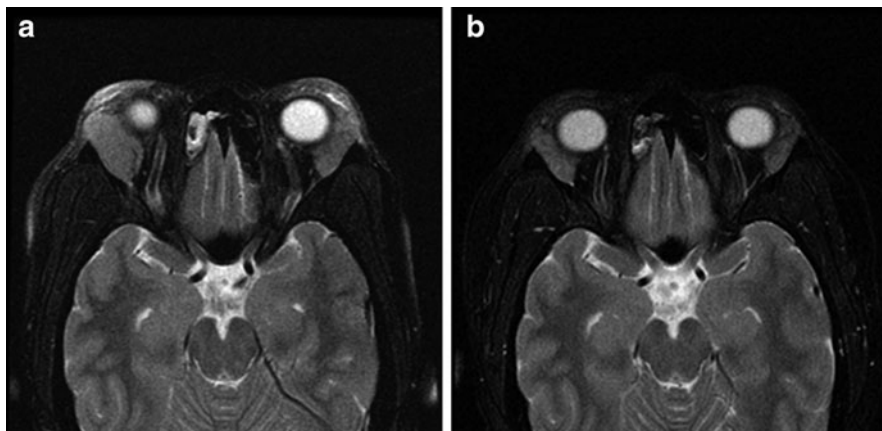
Magnetic resonance imaging of benign lymphoid hyperplasia of orbit before (a) and after (b) treatment with rituximab. From Hao HH, Savar A, Samaniego F, et al. Treatment of benign lymphoid hyperplasia of the orbit with rituximab. *Ophthal Plast Reconstr Surg* 2010;26:11–13. Reprinted with permission
